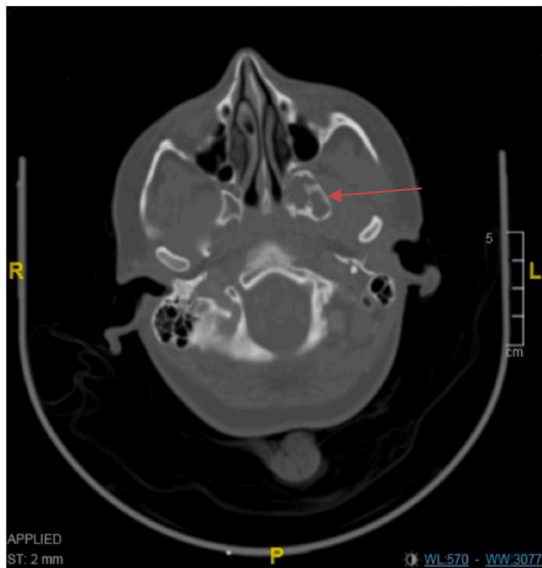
Contrast CT brain bone window, showing a left pterygoid expansile lesion causing erosion in the base of the pterygoid in the left side.
